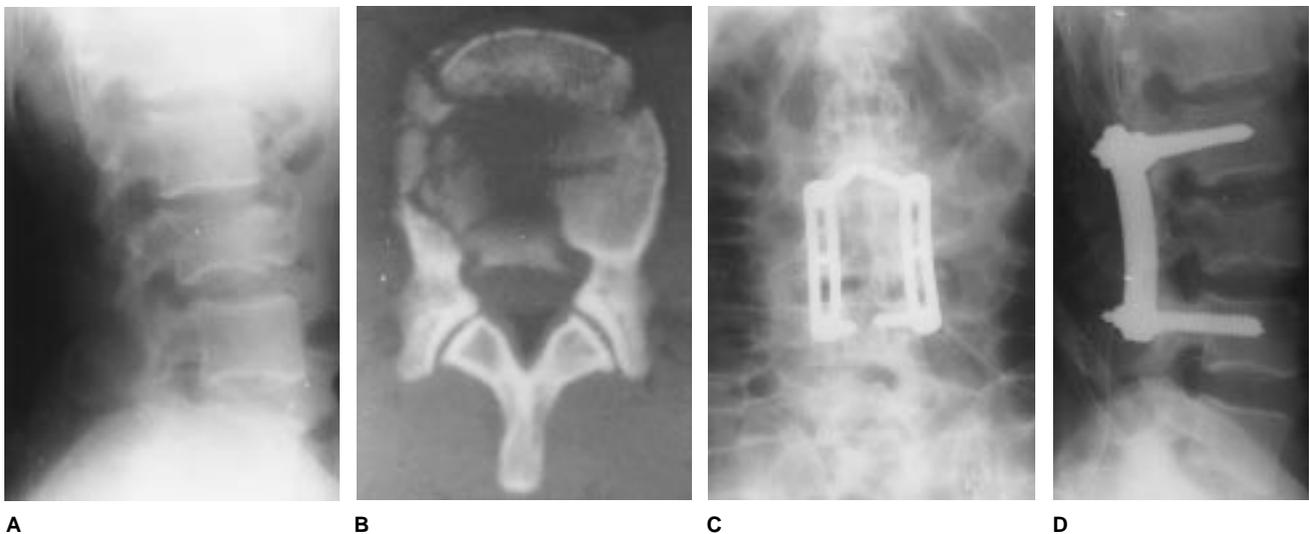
Lateral plain radiograph (A) and transaxial CT scan (B) reveal an L3 burst fracture with approximately 30% canal occlusion. Post-operative AP (C) and lateral (D) radiographs depict posterolateral fusion with short-segment pedicle-screw fixation from L2 to L4.
